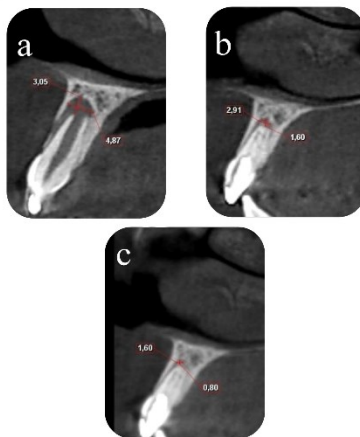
Sagittal CT images of the tooth. a) Before treatment b) 12-month follow-up c) 24-month follow-up
